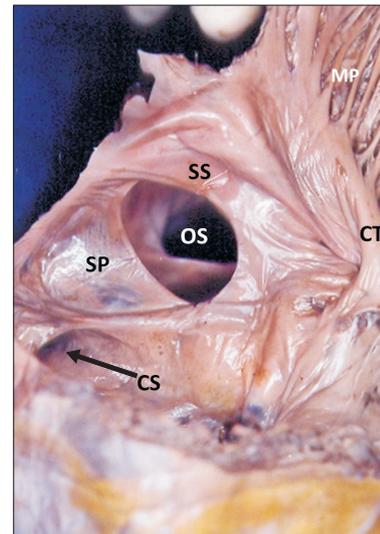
Closer view of the interior of the right atrium. CS, opening of coronary sinus; CT, crista terminalis; MP, musculi pectinati; OS, ostium secundum; SP, septum primum; SS, septum secundum.
